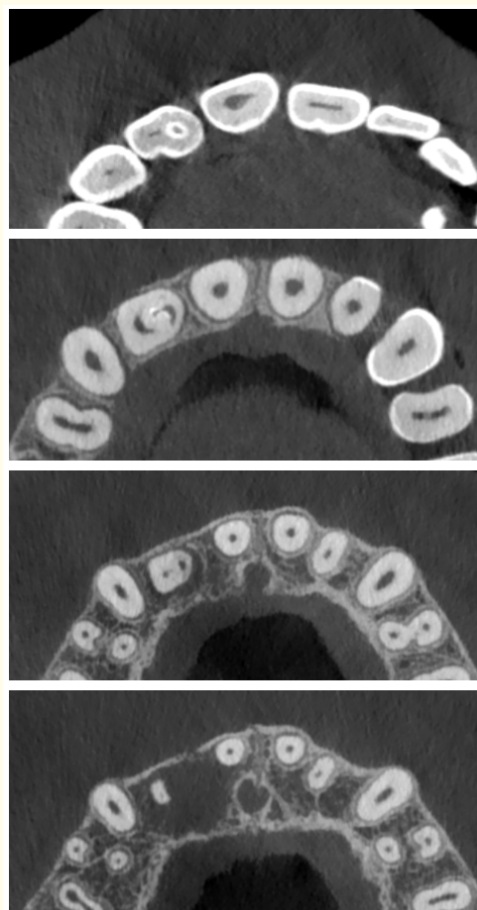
CBCT axial slices demonstrate invagination morphology at different levels and the axial size of the periapical lesion.
